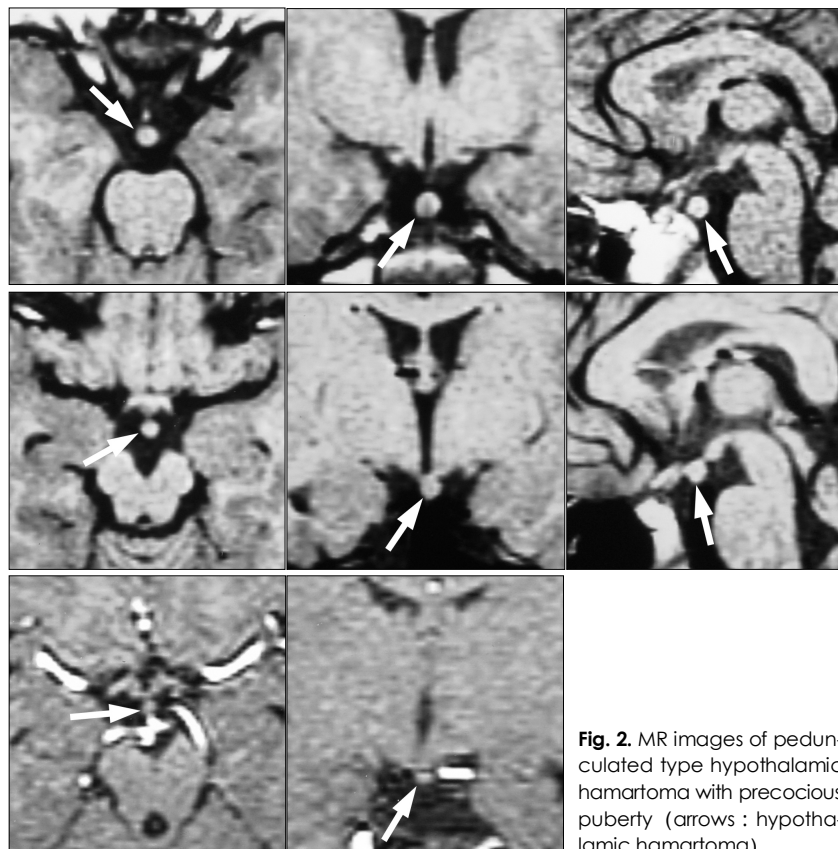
MR images of pedunculated type hypothalamic hamartoma with precocious puberty (arrows : hypothalamic hamartoma).
